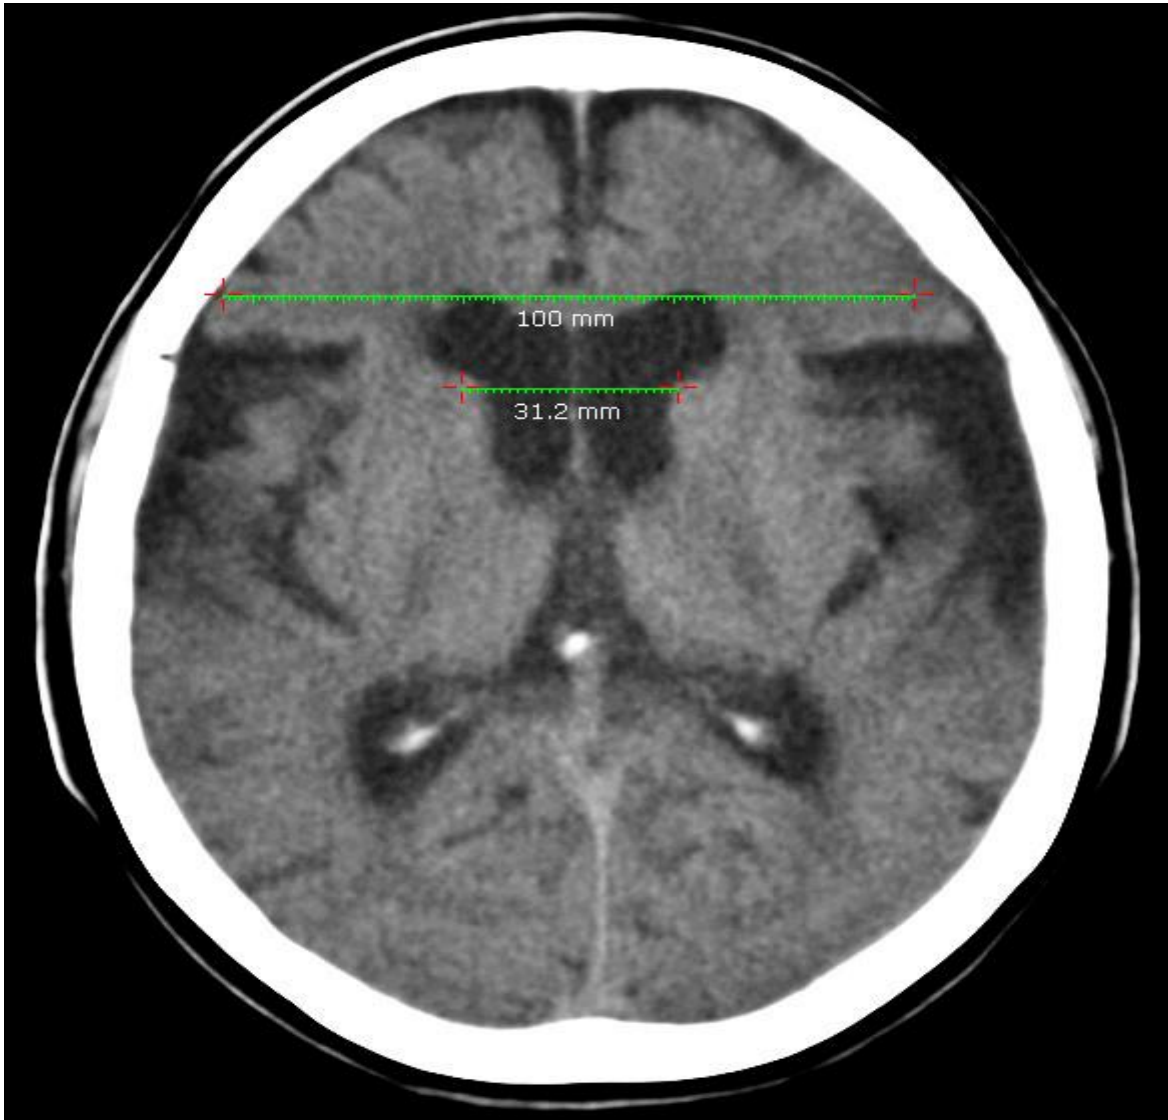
Simple skull CT image of a 75-year-old patient that came to the imagenology ward of Juan Bruno Zayas Alfonso Hospital , without neurologic focalization signs ,it showing signs of cerebral atrophy and an IVE at the level of the frontal horns of the lateral ventricles of 0.31mm.
